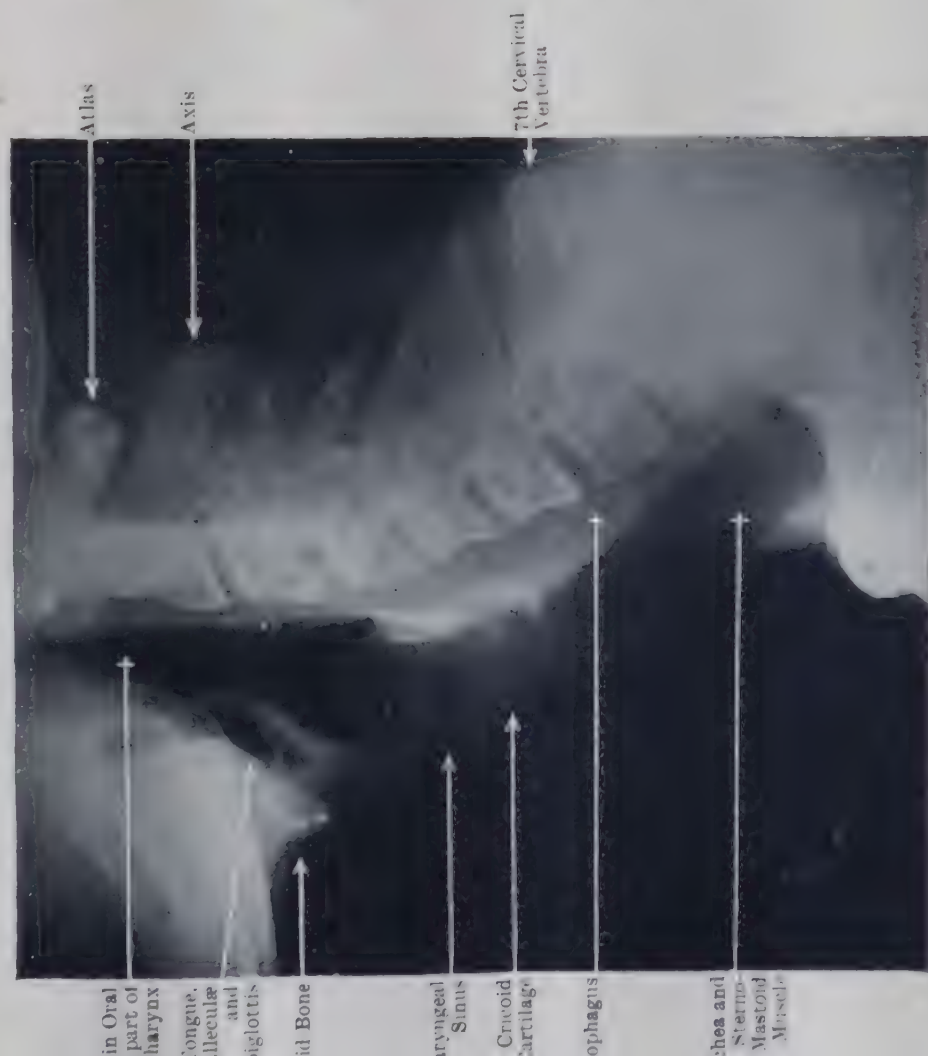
LATERAL RADIOGRAPH OF SLENDER NECK OF WOMAN, SHOWING CAVITIES OF PHARYNX, LARYNX AND TRACHEA AND PARTIALLY-OSIFIED LARYNGEAL CARTILAGES.
